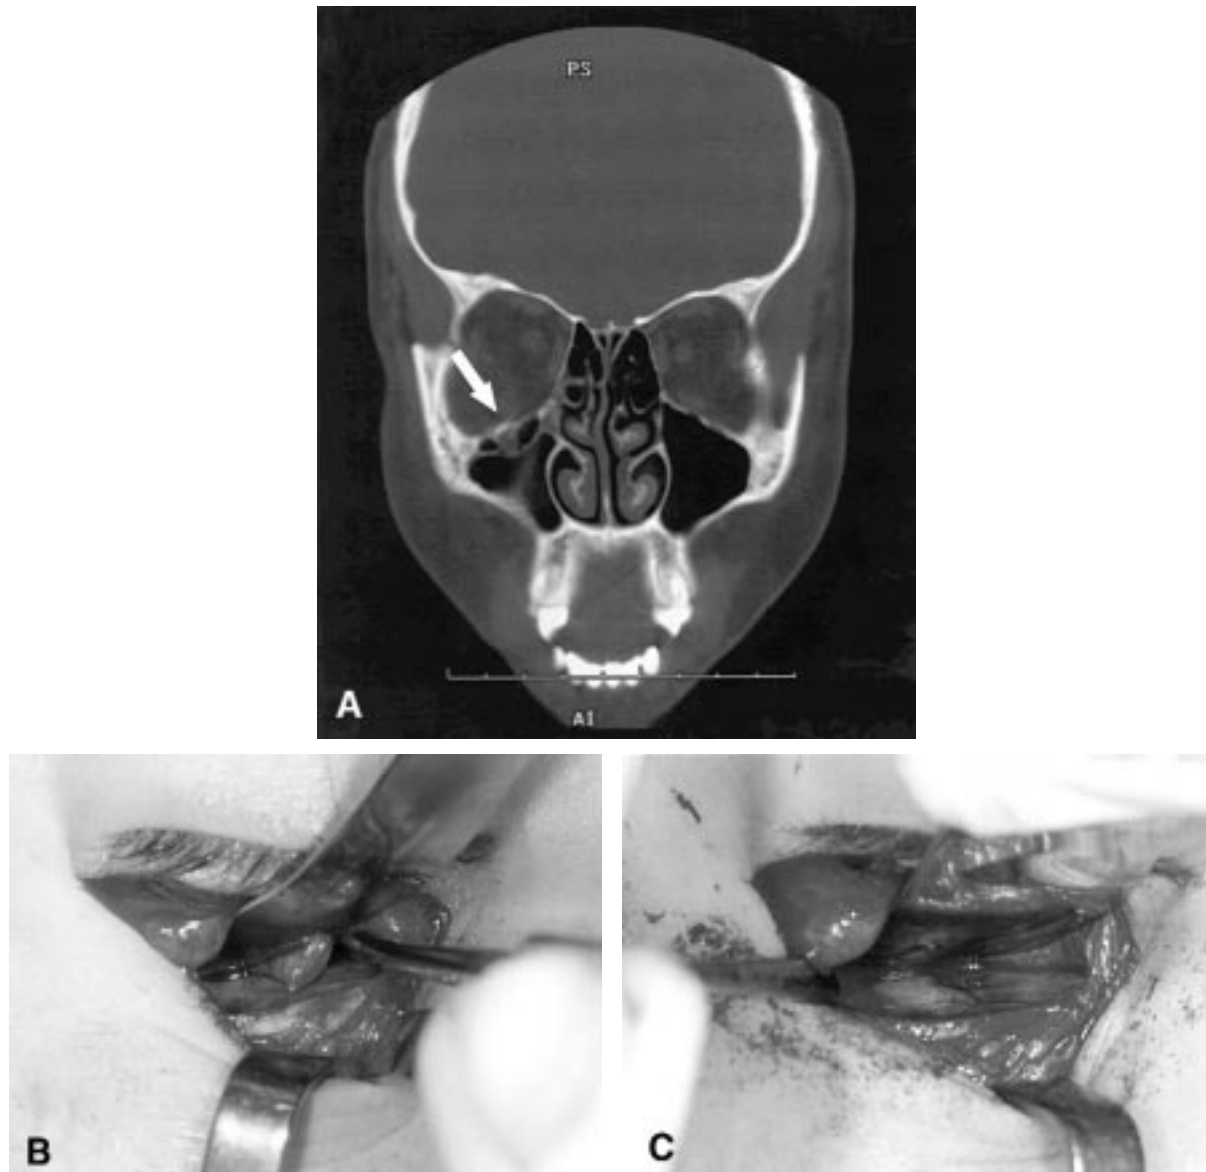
A, CT scan of undislocated orbital floor fracture (arrow) in a 17-year-old girl injured during figure skating who had severe eye pain at presentation. Surgery within 24 hours revealed a trapdoor fracture in the orbital floor before (B) and after (C) the incarcerated soft tissue was released.
